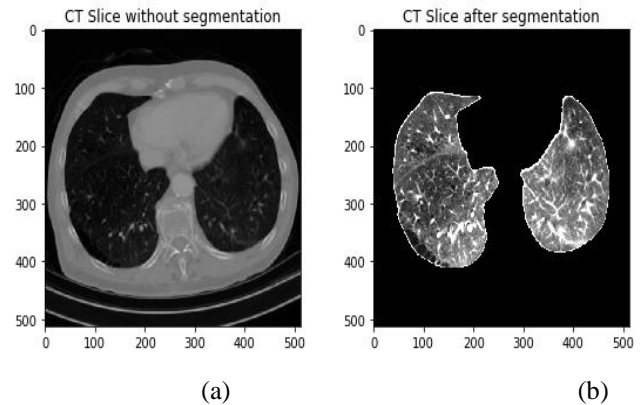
(a) Slice of CT scan without segmentation (b) Slice of CT scan after segmentation.
